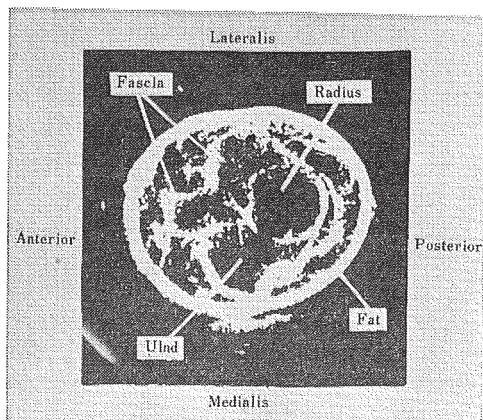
Cross-sectional View of Human Forearm by Ultrasonic Method
